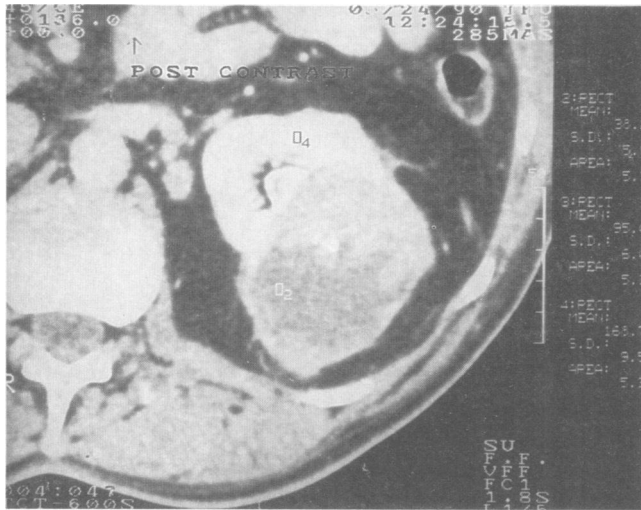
A contrast-enhanced computed tomographic scan through the identical plane seen in Figure 2 shows the areas of contrast enhancement and tissue inhomogeneity characteristic of neovascularity and necrosis within the tumor (O₂).
